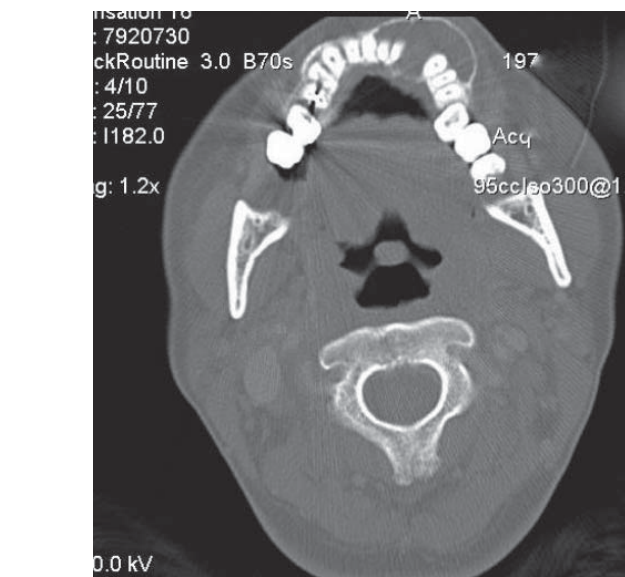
An axial cut of a non-contrast CT showing an expansile, well-defined hypodense lesion of the left maxilla.
